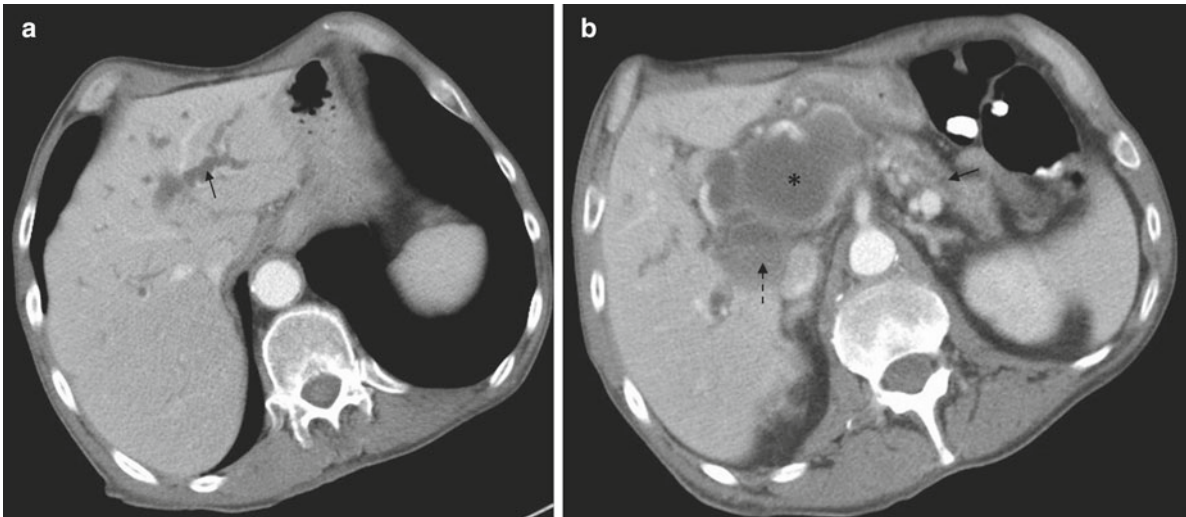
A 72-year-old man presents with chronic upper abdominal pain. (a) Axial oral and intravenous contrast enhanced CT image through the upper abdomen shows intrahepatic biliary dilatation (*black arrow*). (b) Axial oral and intravenous contrast enhanced CT image
